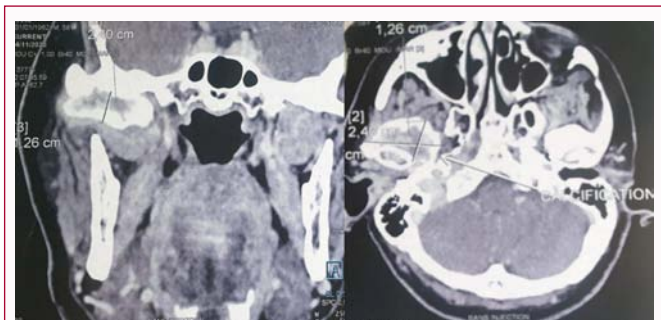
Craniofacial CT showing an intra-articular tumor.
